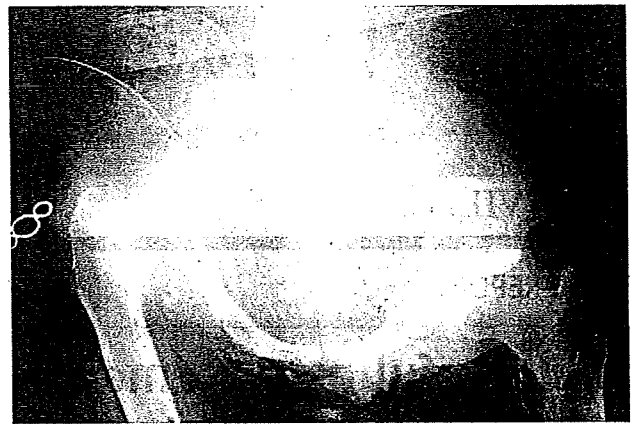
Pelvic roentgenogram. Note the total defects of bilateral inferior pubic ramus and ischium to the acetabular rim.
